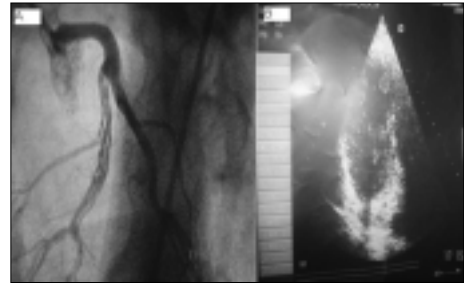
A- Preoperative coronary angiography shows dissection of left anterior descending artery. B- Preoperative echocardiography shows a cardiac apical mass of left ventricle
